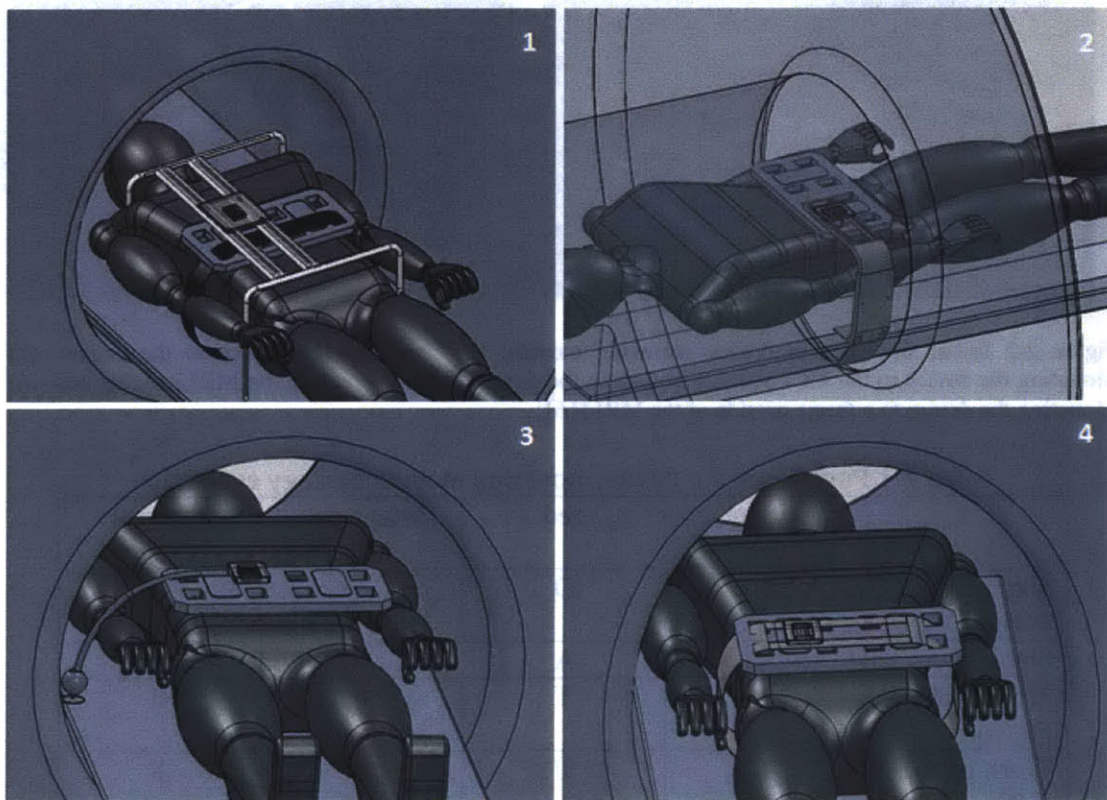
Device mounting module concepts. (1) Concept 1 uses a belt to wrap the device on the patient. Telescoping legs resting on the bed would provide extra stability. (2) Concept 2 attaches to the side of MRI bed and can accommodate for patient size/cancer location with a telescoping arm. (3) Concept 3 also connects to MRI bed, with curved telescoping arm to provide reach and structural support. (4) Concept 4 secures the device and imaging coil with a belt or pre-curved plastic.
